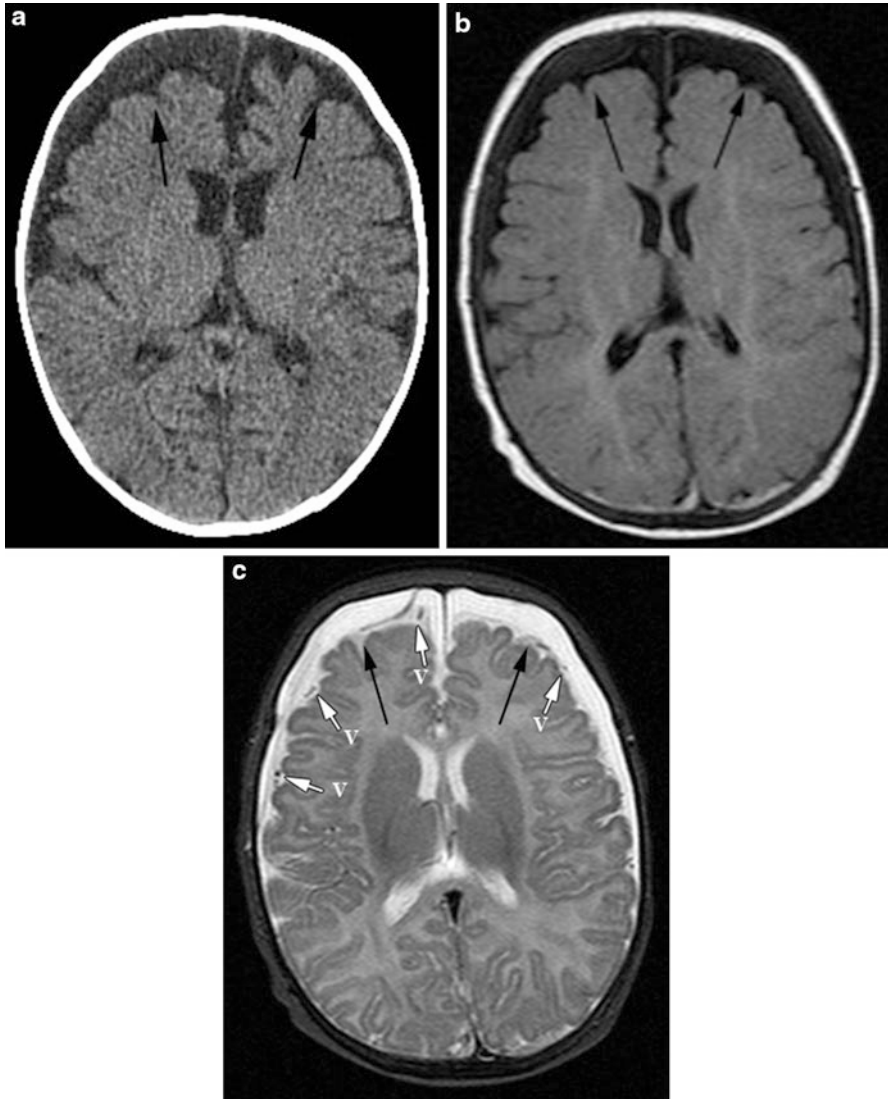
Chronic SDH without rebleed. An axial image from a noncontrast CT scan (a) and axial T1-weighted (b) and T2-weighted (c) images from an MRI show bilateral extra-axial collections (*black arrows*) which are slightly hyperdense to CSF on CT and are slightly hyperintense to CSF on MRI. Notice the displacement of the cortical vessels (V) away from the inner table of the skull
